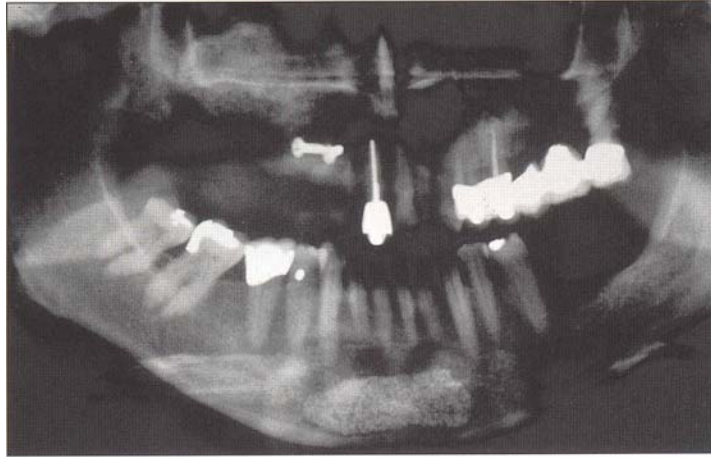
Postoperative panoramic radiograph of the sinus graft and fixed block graft.
